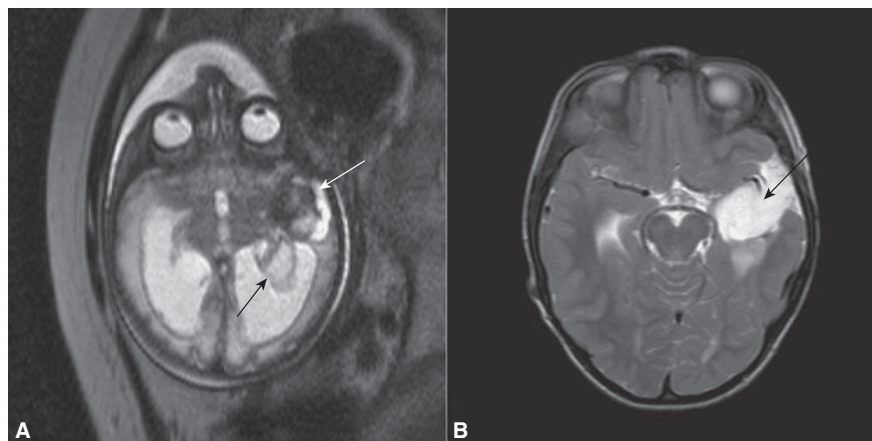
Primitive neuroectodermal tumor. (A) Fetal brain MRI at 34 weeks of gestation shows the mass involving the brain parenchyma (white arrow) and extending into the lateral ventricle (black arrow). Note the presence of marked ventriculomegaly. (B) Brain MRI at 5 years of age shows complete remission following surgery. (Courtesy of Daniela Prayer, Vienna, Austria.)
